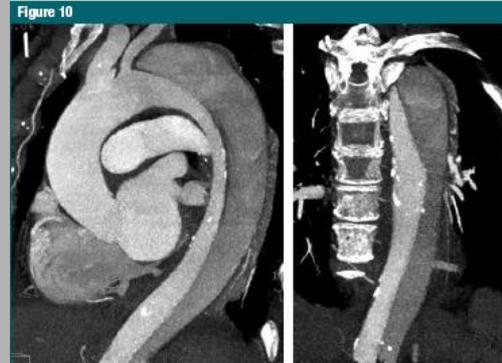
TRO CT angiogram in 70-year-old woman with recent onset of vague chest discomfort. TRO CT demonstrates type B aortic dissection extending from distal aortic arch to descending aorta. (a) Oblique slab MIP image shows entire aortic arch with dissection flap extending into the abdomen. (b) Coronal slab MIP image again demonstrates the dissection with asymmetric enhancement of true and false lumina.
